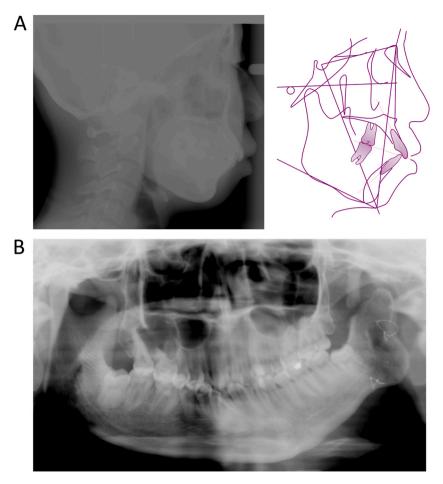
(A) Pretreatment lateral cephalogram and cephalometric tracing. (B) Pretreatment panoramic radiograph.
